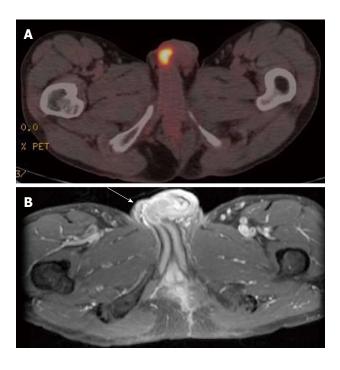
Positron emission tomography and magnetic resonance imaging image. A: Positron emission tomography/computed tomography showing high 18-F fluorodeoxyglucose uptake in the penis; B: Gadolinium-enhanced fatsuppressed T1-weighted image showing a low intensity lesion on the middle penis shaft (white arrow).
